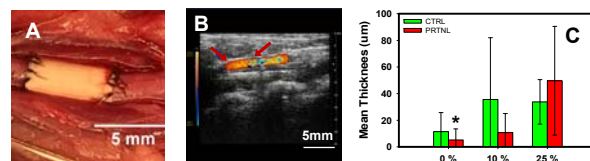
90% PCL graft (A). Ultrasound color Doppler image of the 90% condition (B). Intimal hyperplasia layer thickness (C) (* statistical difference from 75% with peritoneal pre-implantation.)
